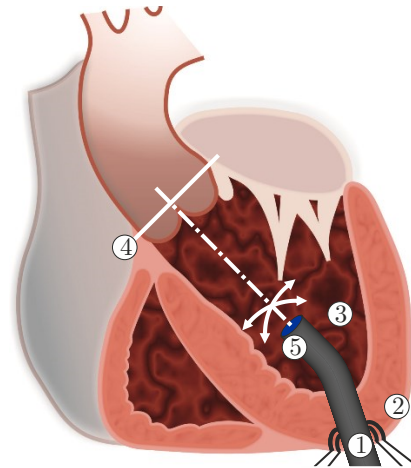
Transapical transcatheter aortic valve implantation can be performed using a robotically-actuated delivery sheath (RADS) to improve valve positioning. The RADS ① is inserted through the apex ② into the left ventricle ③ and oriented perpendicular to the aortic annulus ④ for co-axial alignment. The articulating tip ⑤ of the RADS can be controlled inside the left ventricle under ultrasound image-guidance in two degrees-of-freedom by two pairs of antagonistically-configured tension wires. This enables manipulation of a catheter inside the RADS, and can potentially compensate for beating heart and respiratory motions during surgery.
